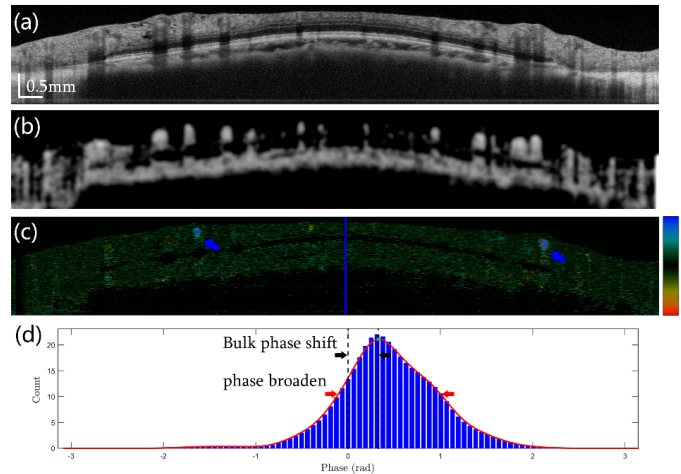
Comparison between OCT angiography and Doppler OCT. (a) Intensity image of optic disk area with circular scan. (b) OCT angiography image and (c) Doppler image in which two vessels required phase unwrapping (blue arrows). (d) Averaged shifted histogram of the A-scan marked by the blue line in (c). The black arrows indicate bulk phase shift and red arrows indicate phase noise of the *in vivo* retina.
